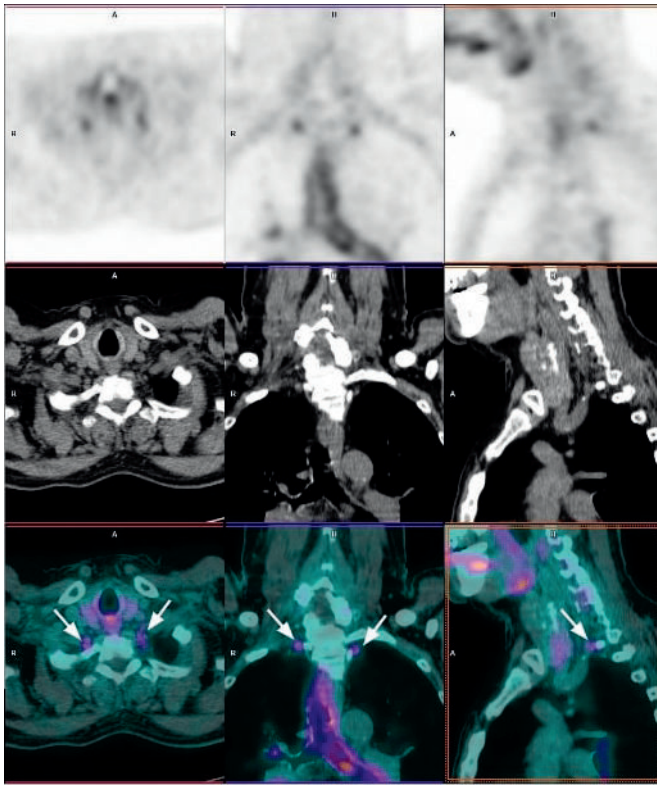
PET, CT and fused PET/CT images (from top to bottom) in transaxial, coronal and sagittal planes (left to right) showing bilateral uptake in cervicothoracic ganglia of the autonomic nervous system (white arrows).
